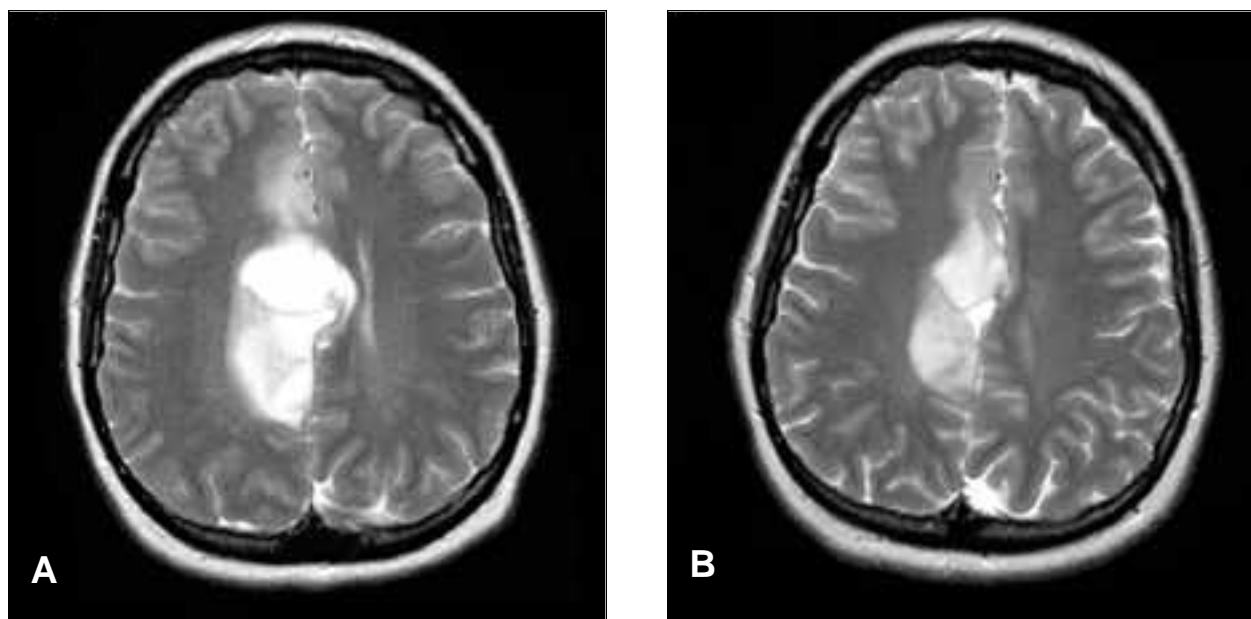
T2-weighted MRI of a 31-year-old woman with a low-grade astrocytoma that progressed radiographically following stereotactic biopsy. Irradiation was deferred because the patient was autistic and would require daily general anaesthesia for radiotherapy. Images before (A) and after 15 cycles of monthly temozolomide chemotherapy (B) demonstrate a partial radiographic response to therapy.
